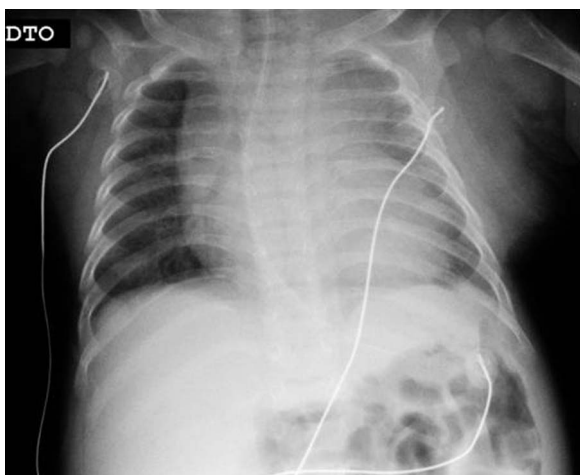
Thoracic radiograph showing diffuse generalised opacity of the left lung and right mediastinum deviation.
